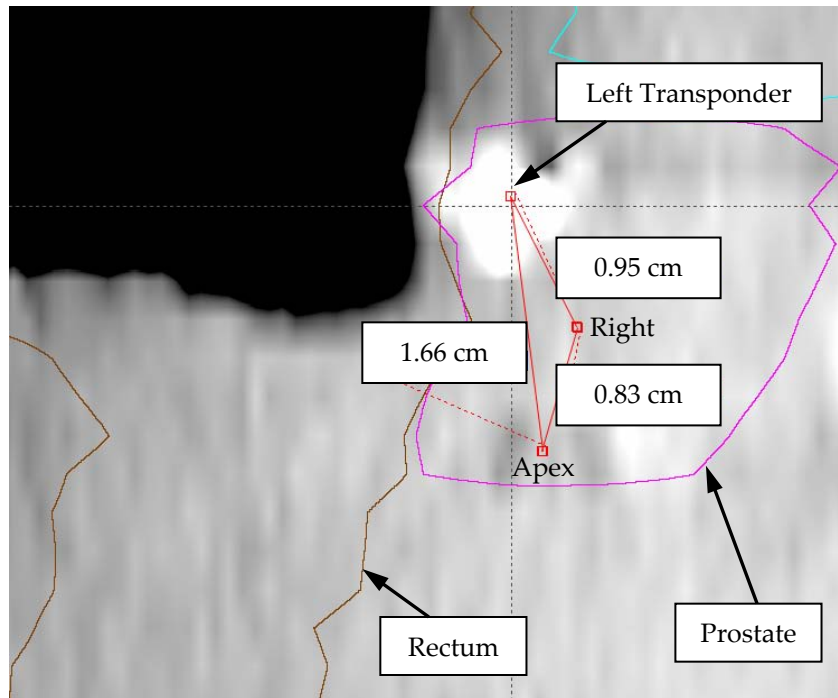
Axial CBCT image of the prostate and rectum. The left transponder is located in the prostate and adjacent to the rectum, as indicated by the arrow.
